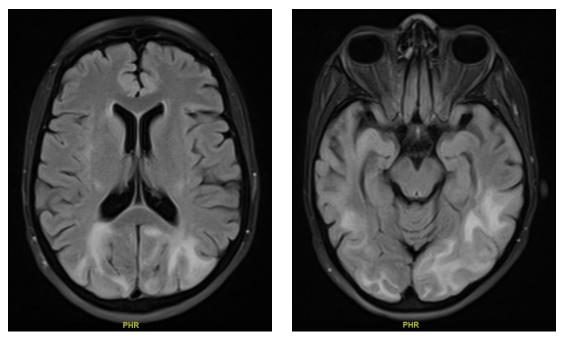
Brain MRI images show multifocal patchy cortical/subcortical edema at the bilateral parieto-occipital and frontal lobes as well as at the body of corpus callosum and bilateral cerebellum sides in keeping with PRES.
